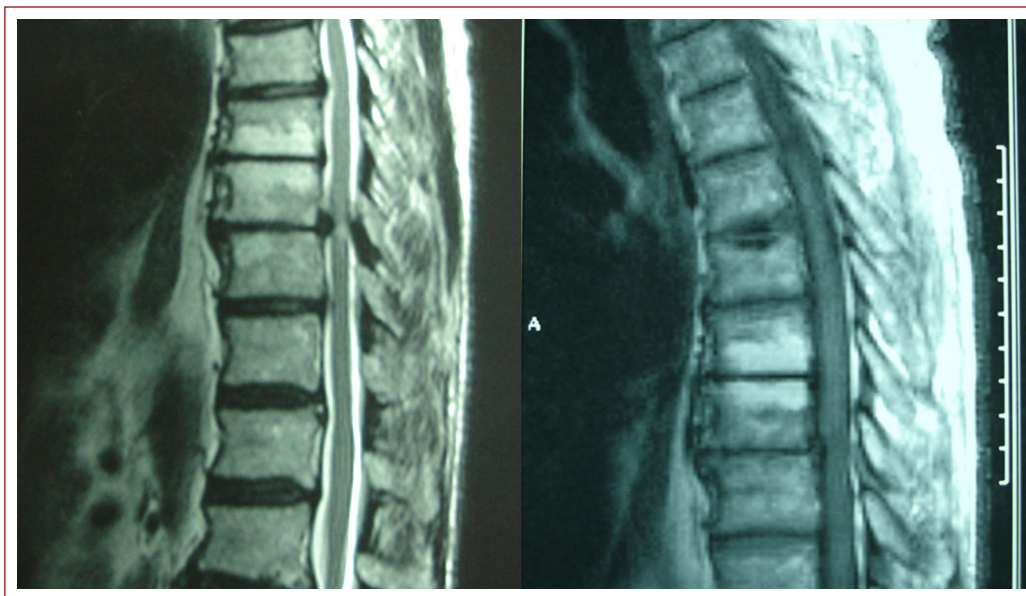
Preoperative (a) and postoperative (b) sagittal T1-W MRI of T7-8 disc herniation. Myelopathy in the spinal cord can be observed.
